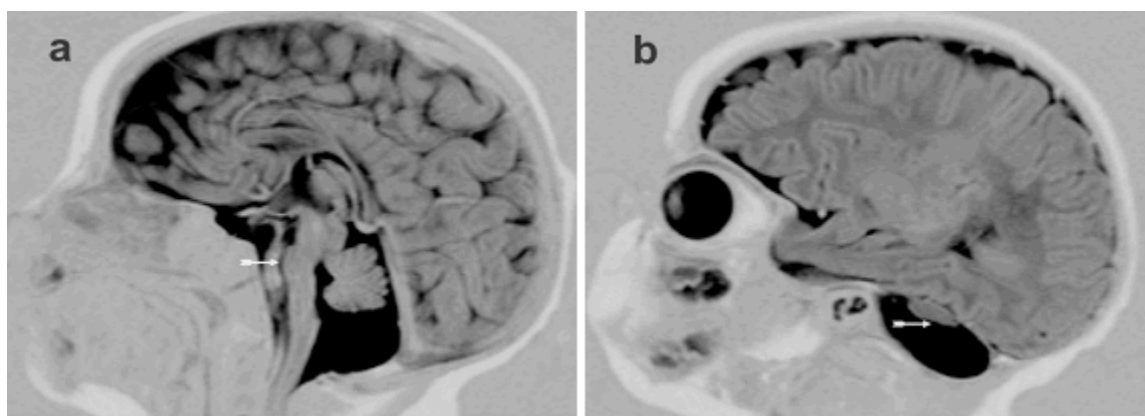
MRI of the brain of an infant age two months with PCH2
